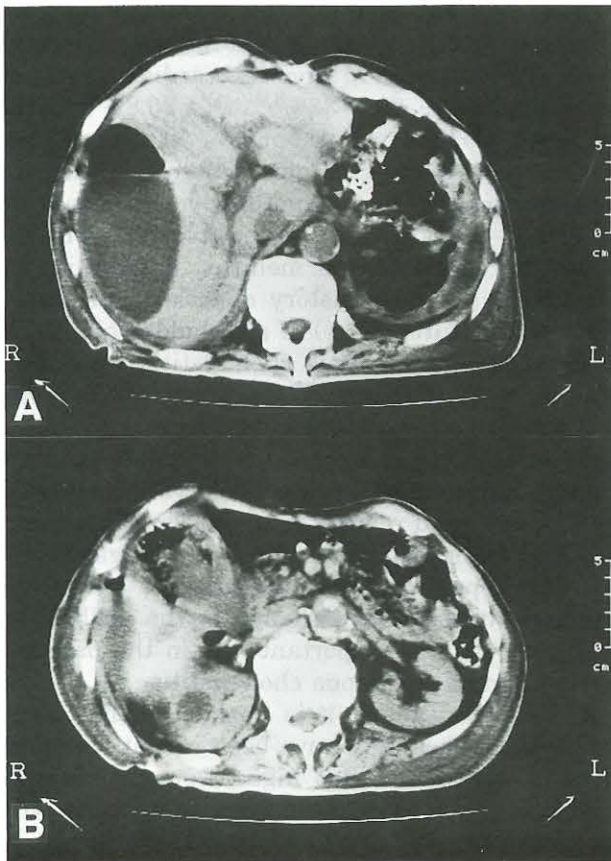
A: CT showing a large gas-containing low-density mass. B: CT showing gas formation within the lumen of the gallbladder.
